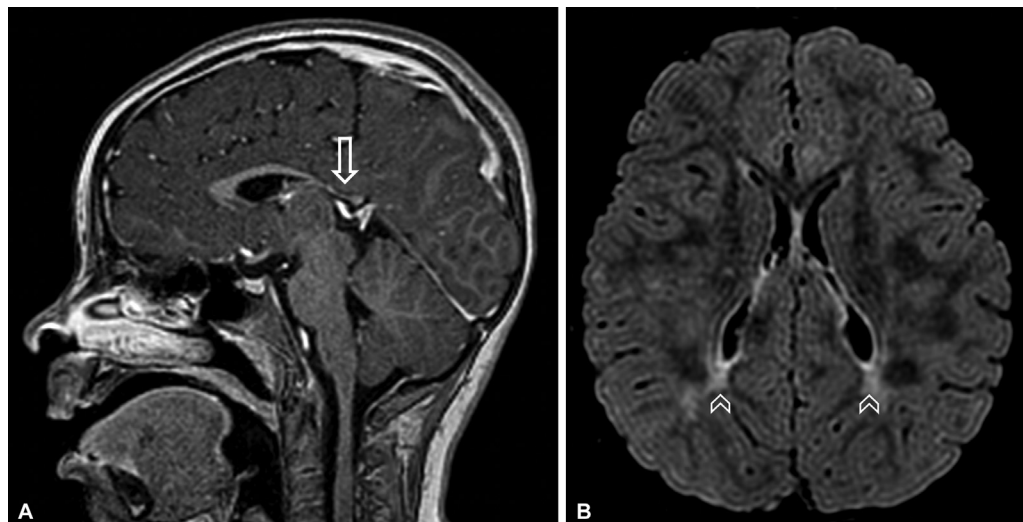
Brain MRI. (A) Sagittal T1 postcontrast shows hypoplastic corpus callosum with marked reduction of the splenium and posterior segment of its body (arrows), characteristic, even though not specific, of this disease. (B) Axial fluid-attenuated inversion recovery (FLAIR) demonstrates symmetric and bilateral peritrigonal white matter changes (arrowheads). The ears of the lynx sign is not usually observed in these cases.
